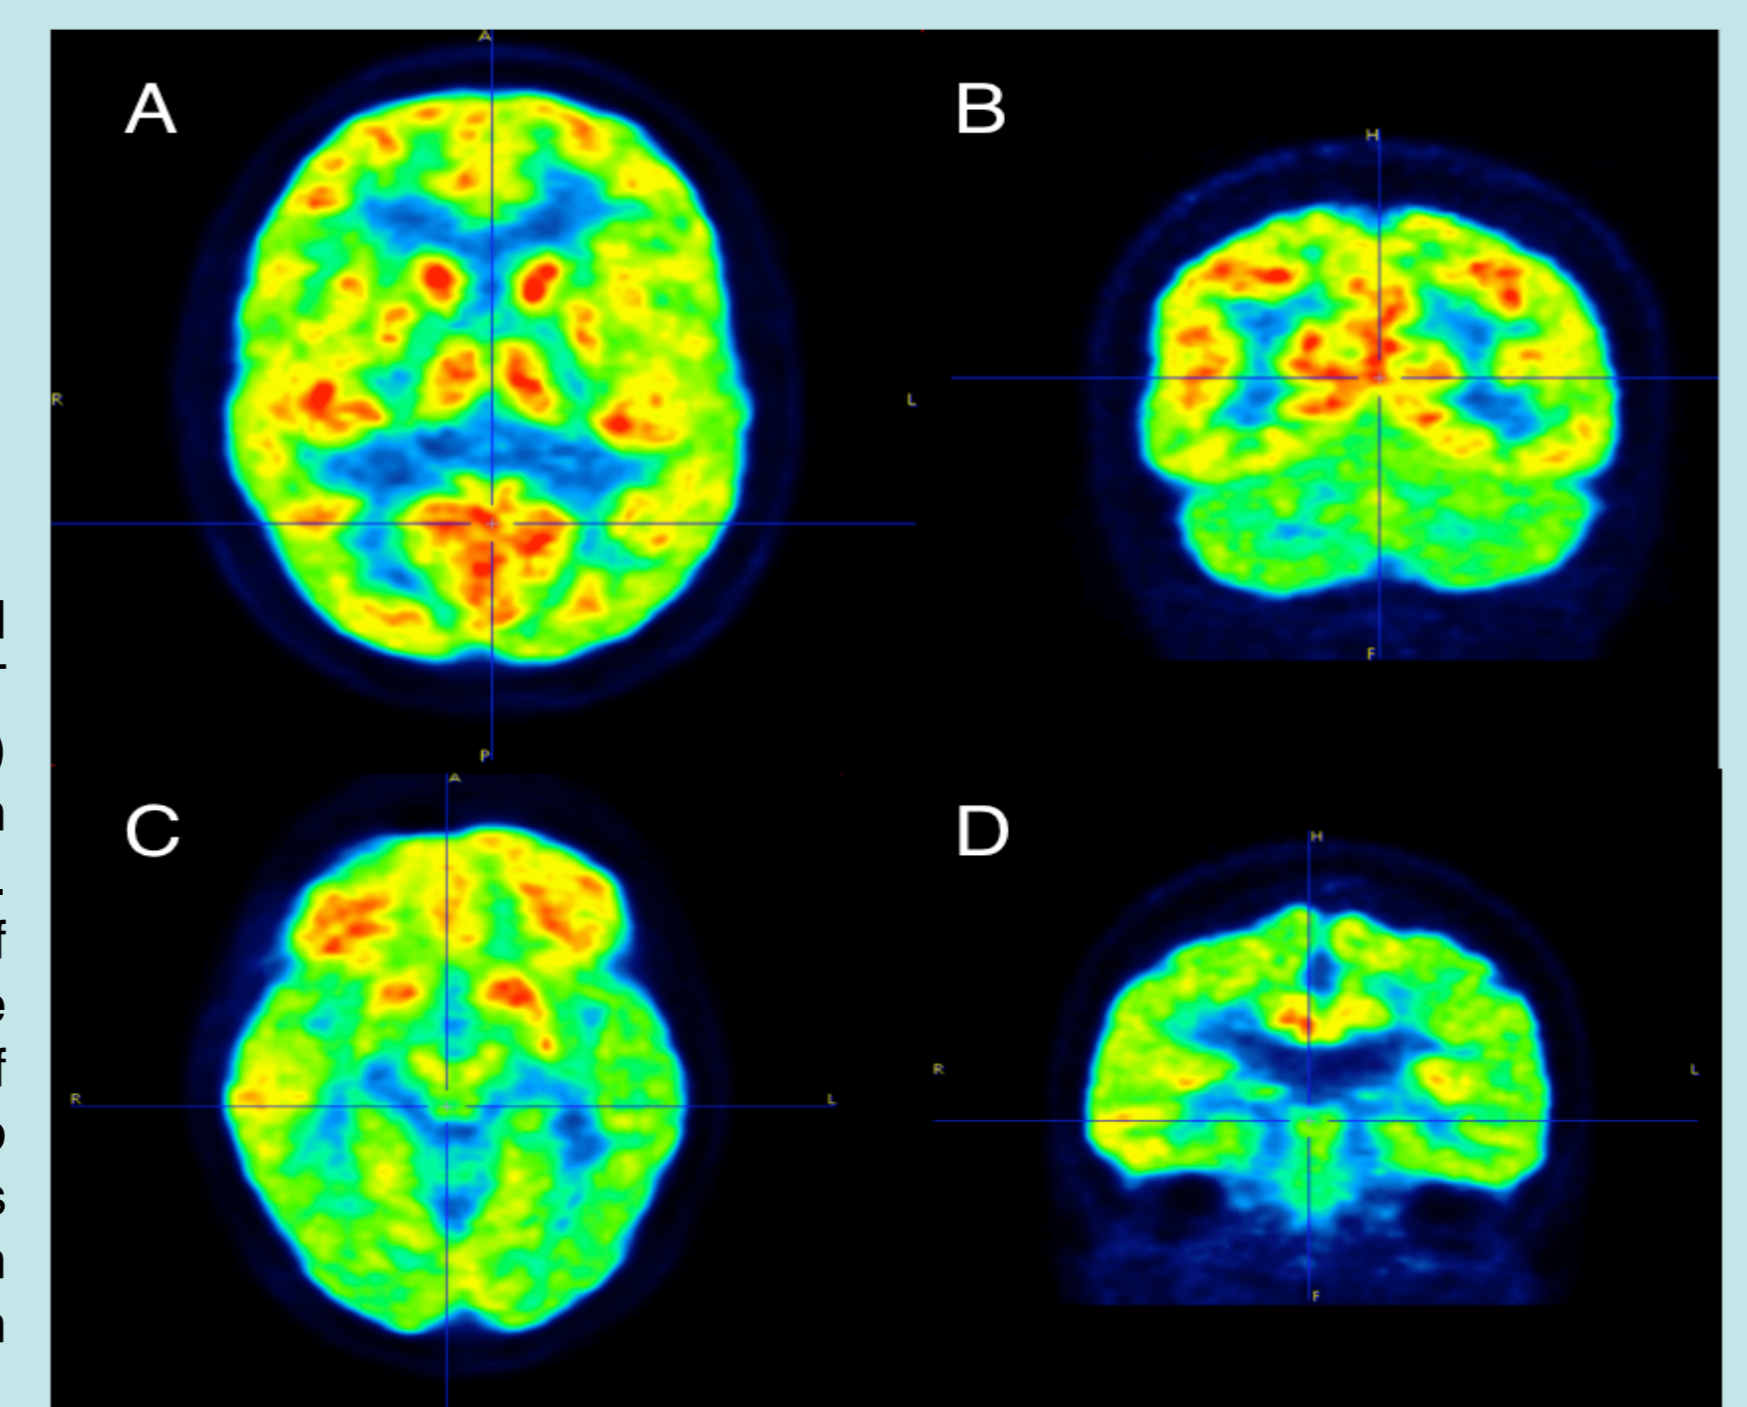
Axial and coronal 18F-FDG PET images of a CIS (A, B) and a RRMS patient with cognitive decline (C, D). In both cases areas of hypometabolism can be observed. The similarity of the images in these two different patients shows the complexity in distinguishing CIS from RRMS.
